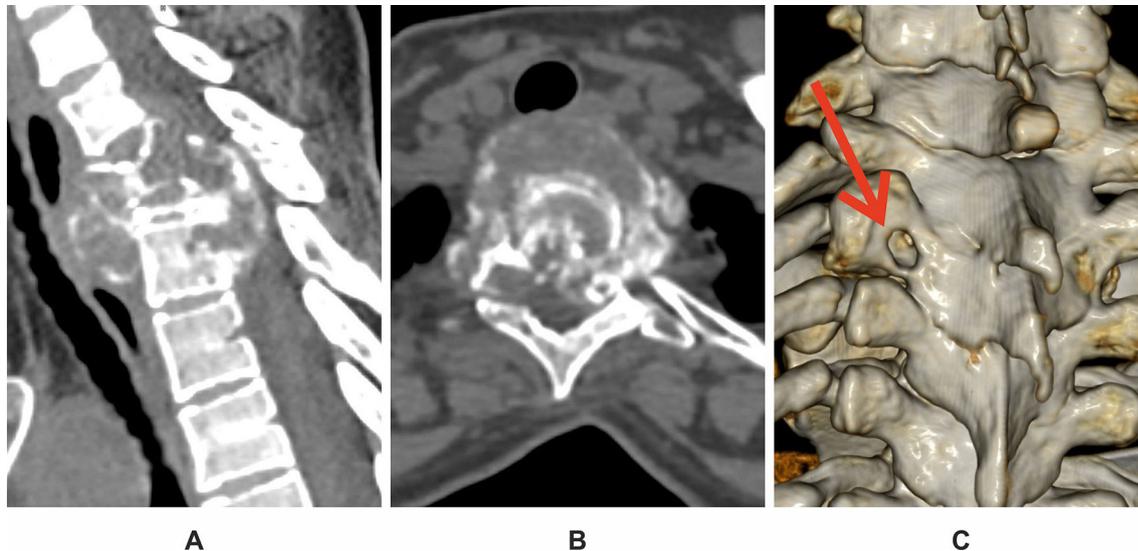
Spiral computed tomography of the cervical-thoracic junction area during hospitalization: A – sagittal reconstruction; B – section at the level of the Th2 vertebra; C – 3D reconstruction. Posterolateral projection. The arrow indicates the postoperative arch defect
